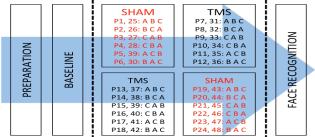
After baseline assessment (session 1) participants are assigned to either of two condition sequences (sham or TMS) dispersed over two independent sessions (2 & 3) In both conditions three locations (A = mPFC, B = RTPJ, C = LTPJ) will be targeted. The order of these locations is counterbalanced within participants. After completion, participants conduct a facial recognition task. Single biphasic TMS pulses will be administered with a Nexstim Ltd. eXimiaTM stimulator and a Nexstim biphasic 70 mm figure-of-eight coil while reducing TMS-induced noise and fixing the head position using a chin rest. Before stimulation, a high-resolution T1-weighted anatomical MRI-image of the brain will be acquired from participants. Impulses will be directed to targeted areas using the Navigated Brain Stimulation system that registers the relationship between the coil and the brain with a spatial resolution of 2 mm. P1-48 = participant numbers.
